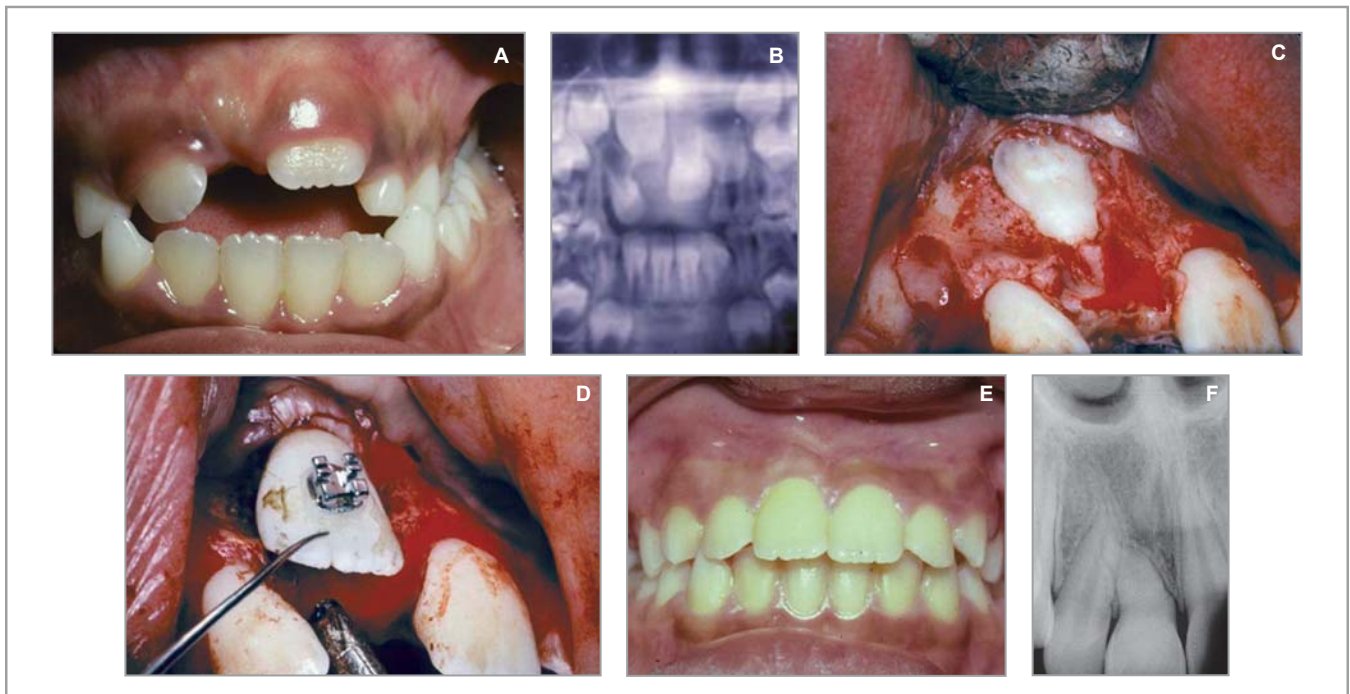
(A–F) Some teeth that are displaced can benefit from reorientation (transplantation in situ). (A) Unerupted maxillary right central incisor. (B) Panoramic radiograph showing the inverted tooth. (C) Surgical exposure of the unerupted tooth. (D) Surgical reorientation of the tooth, followed by bonding a bracket. (E) Tooth in final position after orthodontic traction. (F) Periapical radiograph showing shortened and dilacerated but functional root.
